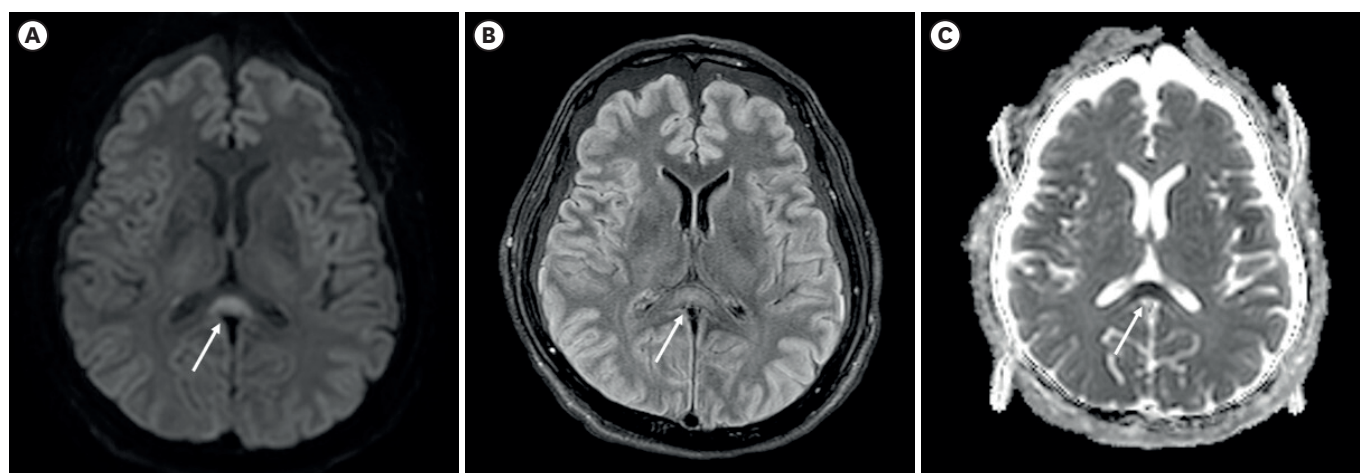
Magnetic resonance imaging findings in cytotoxic lesions of the corpus callosum. (A) Diffusion-weighted imaging and (B) fluid-attenuated inversion recovery show high signal intensity. (C) The apparent diffusion coefficient map shows hypointense signals in the same lesion, indicating restricted diffusion (arrow).
